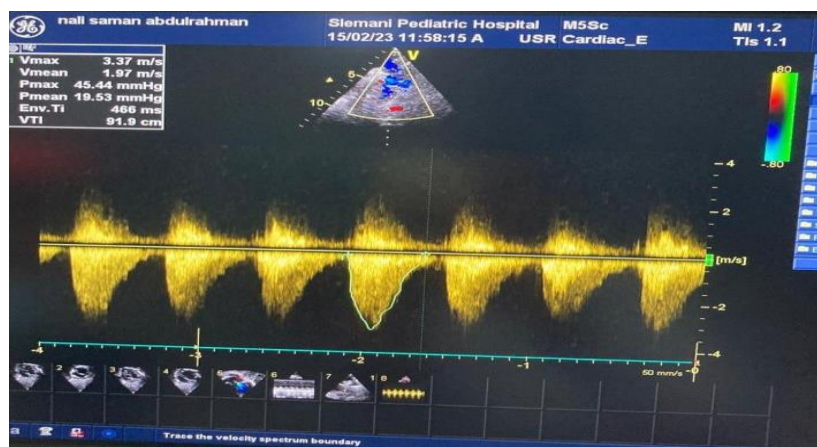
Echocardiographic Doppler Study Showing trace the velocity with maximum and mean pressure gradient across the arch after intervention.
